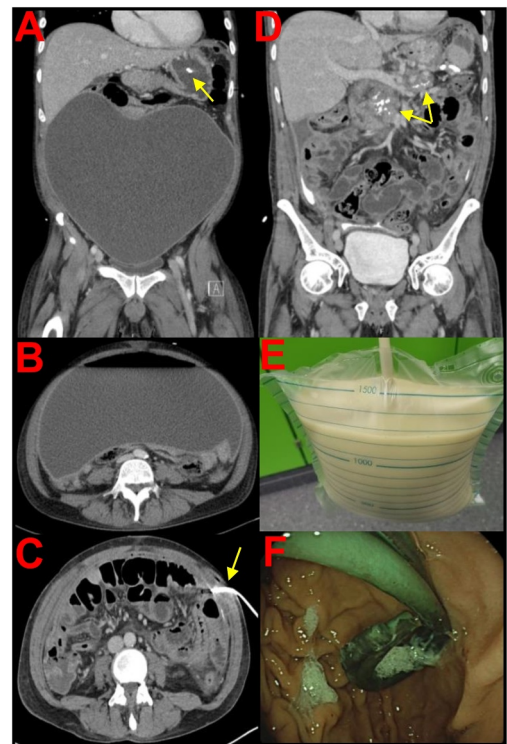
CT imaging of the pancreatic “supercyst” before (a, b) and after percutaneous drainage (c, d) of purulent fluid (e). (f) Endoscopic view of intraluminal drainage placed 1 year ago.
